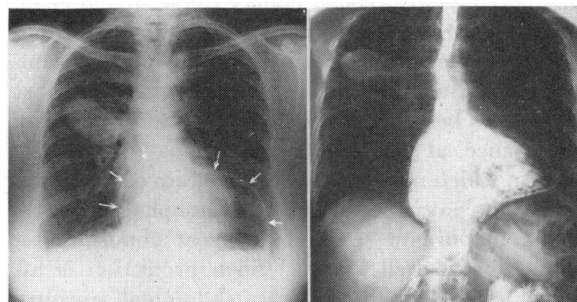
Completely asymptomatic large hiatal hernia, outlined by arrows in the plain film of the chest (left) and in a later film (right) by barium, in a patient being treated for a tuberculoma of the right upper lobe.
